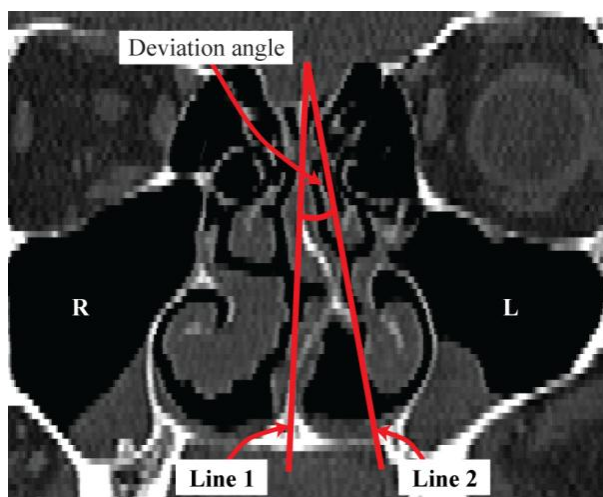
Coronal paranasal sinus CT image demonstrating technique for measurement of the septal deviation angle. R and L are the right and left side of the nose.
